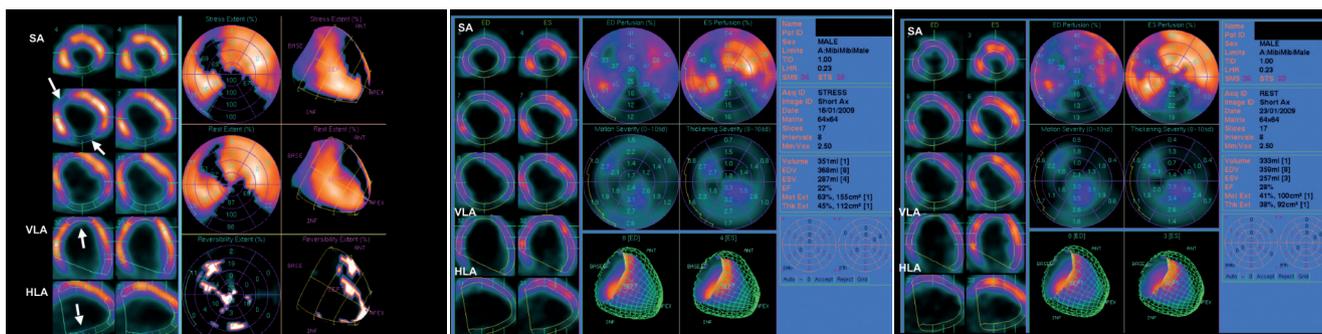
Example of a dobutamine stress gated $^{99\text{m}}\text{Tc}$ -sestamibi SPECT study in ischaemic left ventricular dysfunction for assessment of myocardial perfusion and function. A. Dobutamine stress gated $^{99\text{m}}\text{Tc}$ -sestamibi SPECT in a male patient with a history of myocardial infarction and coronary bypass surgery. Left column, from top to bottom: short-axis (SA), vertical long-axis (VLA) and horizontal long-axis (HLA) slices. There is a fixed perfusion defect in the anterior, septum, inferior and apical regions (white arrows). The polar maps in the middle and right column confirm these fixed perfusion defects and demonstrate limited defect reversibility at the borders of the fixed perfusion defect. This was reflected by the summed stress score (SSS) of 24, the summed rest score (SRS) of 18, resulting in a summed difference score (SDS) of 6. B. Continued: quantitative analysis of the dobutamine SPECT images. Left column: end-diastolic (ED) and end-systolic (ES) slices demonstrating extensive wall motion abnormalities, most pronounced in the regions with the fixed perfusion defects. Middle column from top to bottom: ED and ES polar plots, quantitative analysis demonstrating extensive and severe wall motion abnormalities and abnormal wall thickening. The summed wall motion score (SMS) is 34 and the summed thickening score (STS) is 25. The left ventricle is severely dilated with an end-diastolic volume of 368 ml and an end-systolic volume of 287 ml, the left ventricular ejection fraction (LVEF) at stress is 22%. C. Continued: quantitative analysis of the resting SPECT images demonstrating extensive wall motion abnormalities and abnormal wall thickening in the anterior, septum and inferior regions. The SMS is 28, STS is 23, and the LVEF at rest is 28%.
